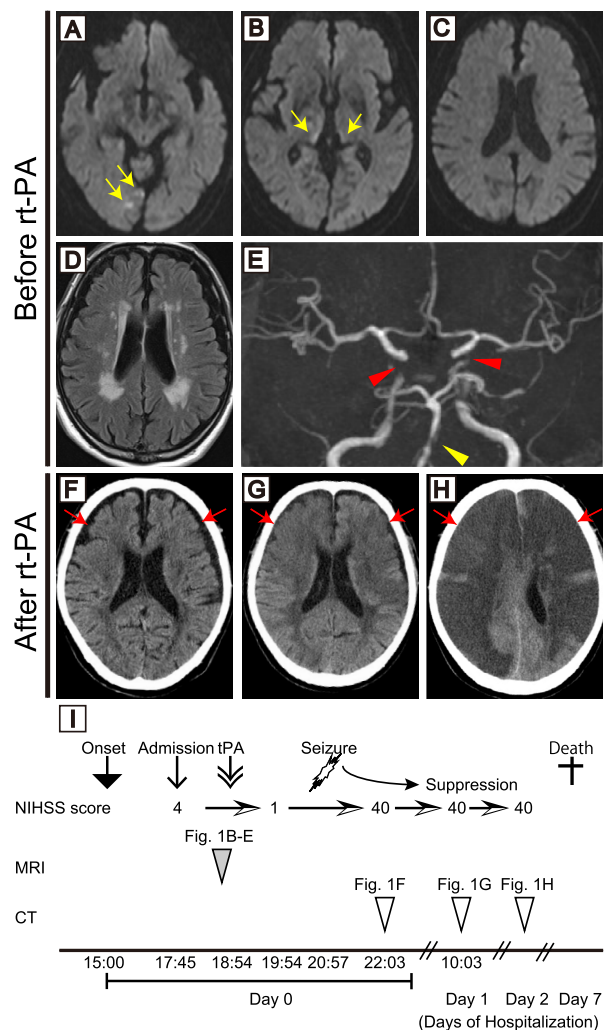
(A-D) Cranial magnetic resonance imaging (MRI) and (E) magnetic resonance angiography (MRA) before intravenous recombinant tissue plasminogen activator (IV rt-PA) therapy. (A-C) Cranial diffusion-weighted imaging (DWI) and (D) fluid-attenuated inversion recovery (FLAIR) imaging. (E) MRA view. Red arrowheads show internal carotid artery stenosis, and yellow arrowheads show basilar artery stenosis. The Diffusion-Weighted Imaging-Alberta Stroke Program Early Computed Tomography Score (DWI-ASPECTS) was 10. Cranial computed tomography images (F) 3 hours, (G) 16 hours, and (H) 2 days after IV rt-PA therapy. Red arrows show novel bilateral middle cerebral artery infarctions. (I) Summary of the patient's clinical course showing the relationship among events, changes in the National Institutes of Health Stroke Scale, and image examinations. (Color version of figure is available online.)
